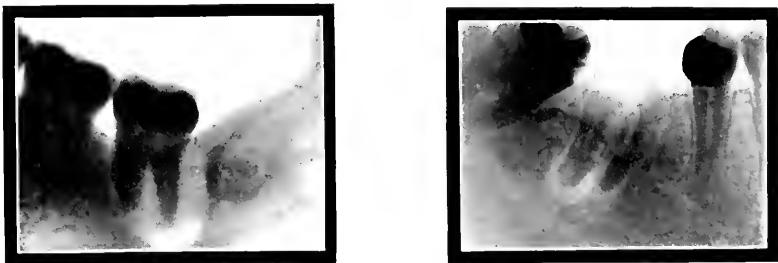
Radiographs of teeth showing the effect of chronic septic pericementitis about the roots.
